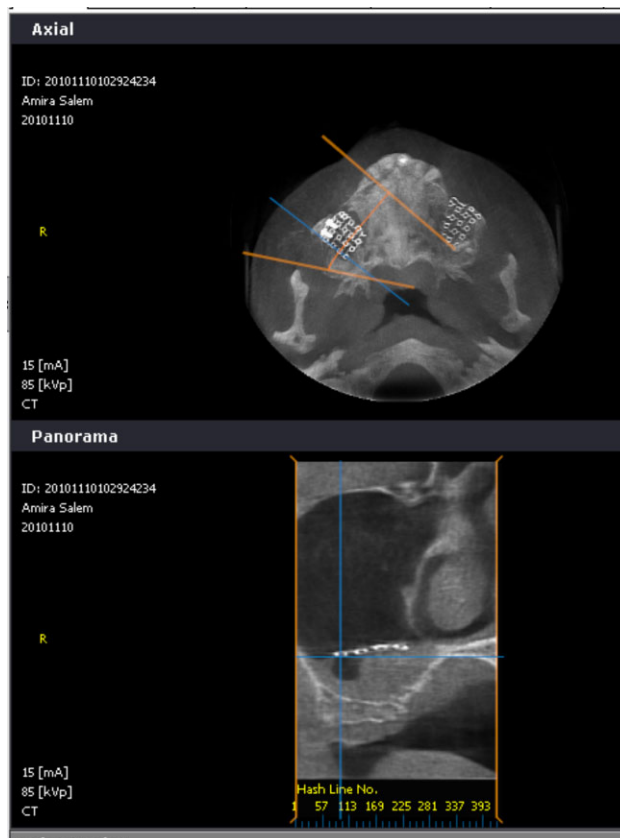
Reformatted MIP axial and panoramic view from the 6 months postoperative CBCT showing selected reference points, delineated by a line drawn passing through the center of the mesh holes.
